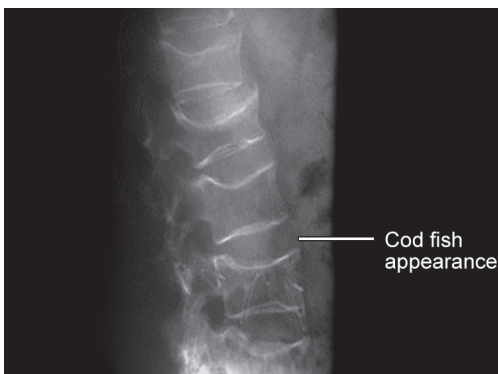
X-ray: Osteoporosis (spine)
